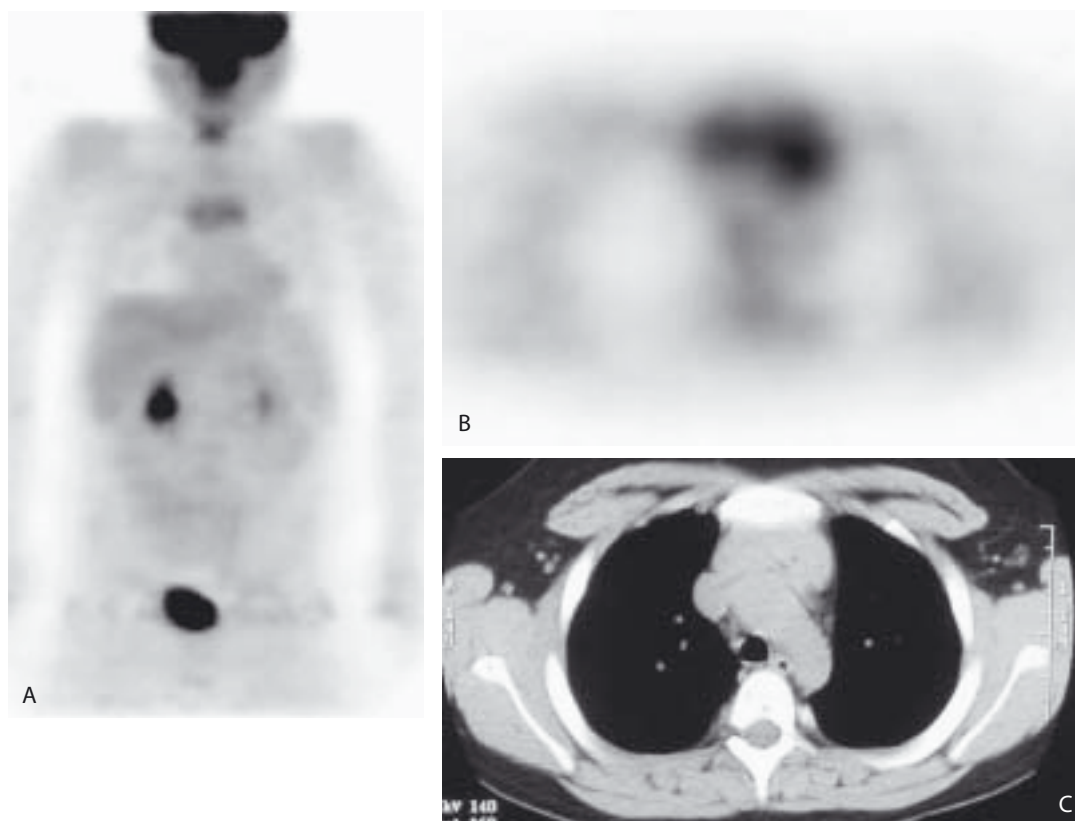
A chest x-ray (not shown) performed on a 13-year-old boy with a history of cough demonstrated a prominent mediastinum. The patient underwent positron emission tomography (PET) and computed tomography (CT) imaging with a presumptive diagnosis of lymphoma. There is mildly increased FDG uptake in the mediastinum on the PET image (A). An axial image (B) confirms the anterior location of this activity, which corresponds to a prominent but otherwise normal, thymus gland on CT (C). The child's cough resolved, and no additional workup was performed.
